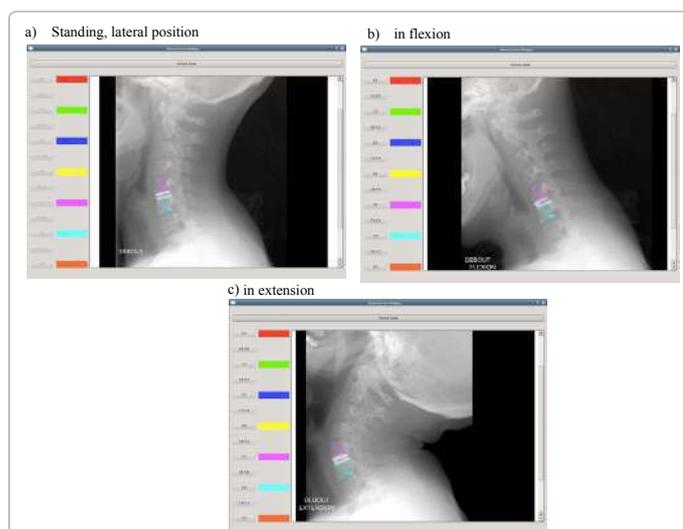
Radiographic images two years after surgery (annotated) Subjects who underwent 1 level (C5-C6) total disc replacement using Baguera®C.
